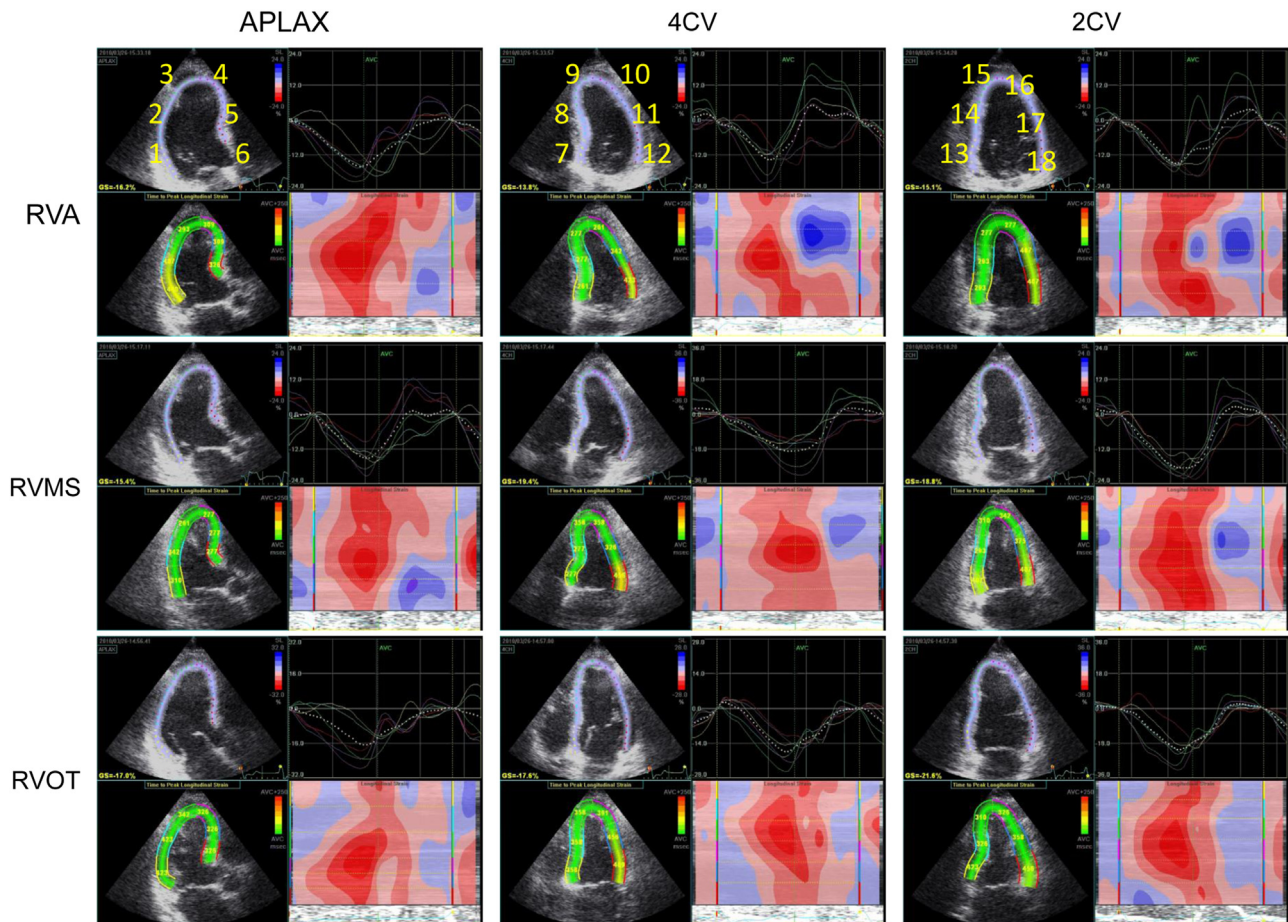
The 2D longitudinal strain echocardiography in an individual patient. The left ventricular (LV) wall was divided in 18 segments (Nos.1–18), each revealing a longitudinal strain curve and an individual time to peak strain. Using this method, the differences in the LV synchronization could easily be quantified at each pacing site. The upper panels show the right ventricular apical pacing. The middle panels show the right ventricular outflow-tract mid-septal pacing. The lower panels show the right ventricular outflow-tract pacing. APLAX, apical long-axis view; 4CV, four-chamber view; 2CV, two-chamber view.
